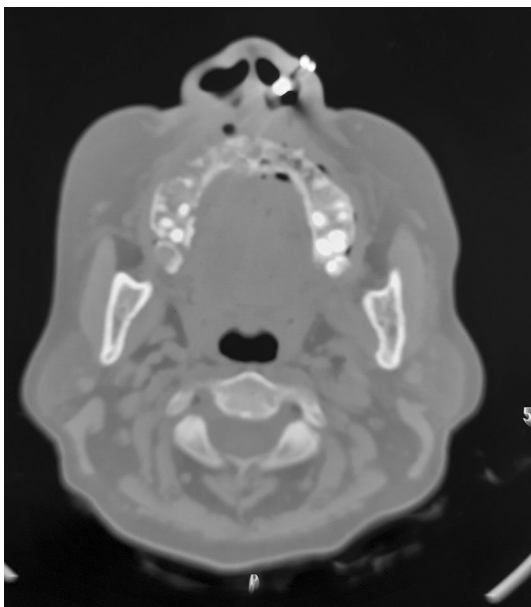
CT scan showing bony window of CAM affected bilateral maxilla
